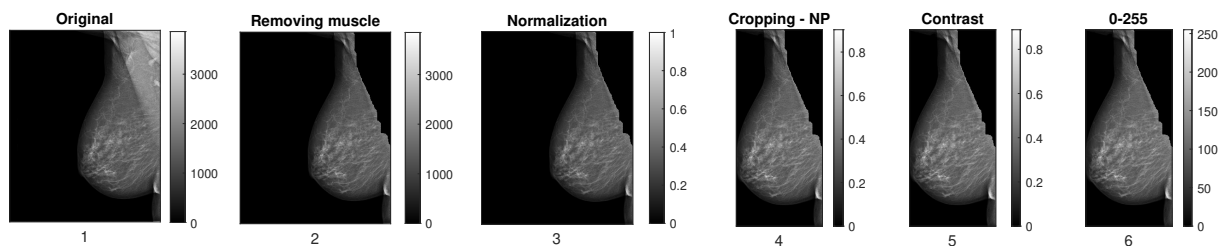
Steps of preprocessing block for X-ray mammogram images: the original image received from the Medical University of Vienna (1), removing muscle from the image using the proposed methods (2), normalizing the image (3), cropping until the nipple position (4), enhancing contrast using the proposed method (5), and scaling intensities into 0-255 levels (6).
